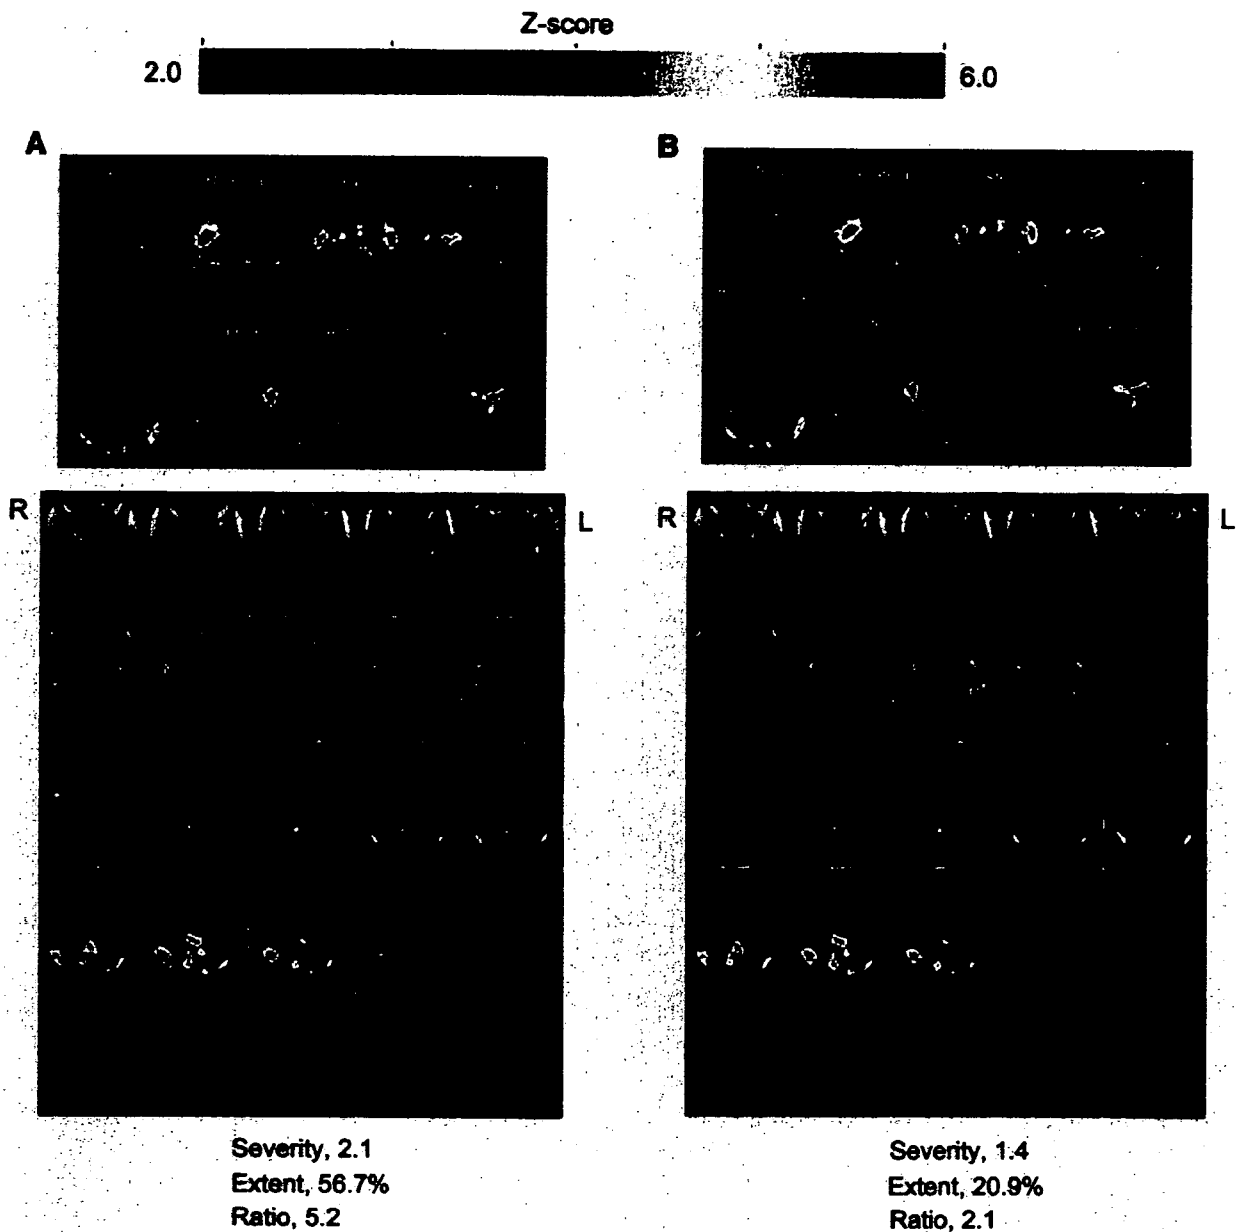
Evaluation with z score mapping system of therapeutic effects of donepezil on brain perfusion SPECT for 68-y-old woman. (A) Baseline study 1 mo before donepezil showed significant decrease in rCBF within specific VOI for early AD. Mini-Mental State Examination (MMSE) score was 5 (out of 30). (B) At 3 mo after start of donepezil administration, all rCBF indices decreased from values at initial study, indicating amelioration of rCBF within specific VOI. MMSE score increased to 14 (out of 30).
